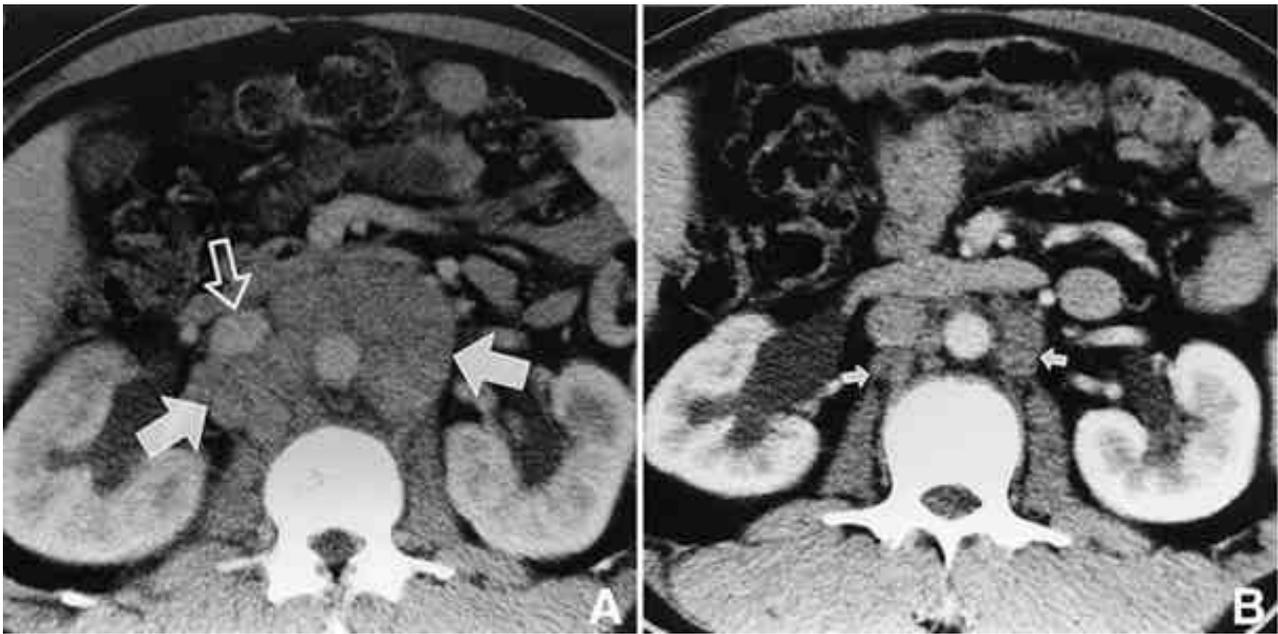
A : Enhanced abdominal CT scan reveals multiple paraaortic lymph nodes (arrows) and anterior displaced inferior vena cava (open arrow). B : Follow-up CT scan after bilateral orchiectomy shows marked decrease in size and number of lymph nodes (arrows).
